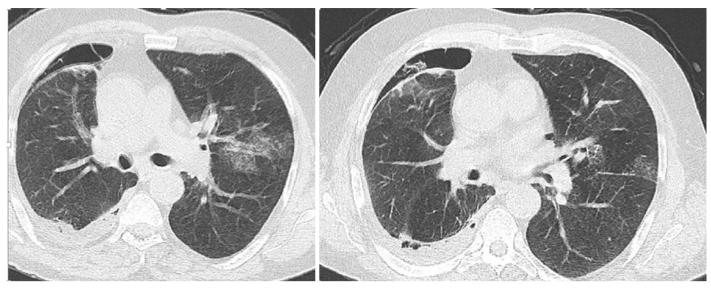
Minimal pneumothorax area in the right lung on thorax computed tomography.
